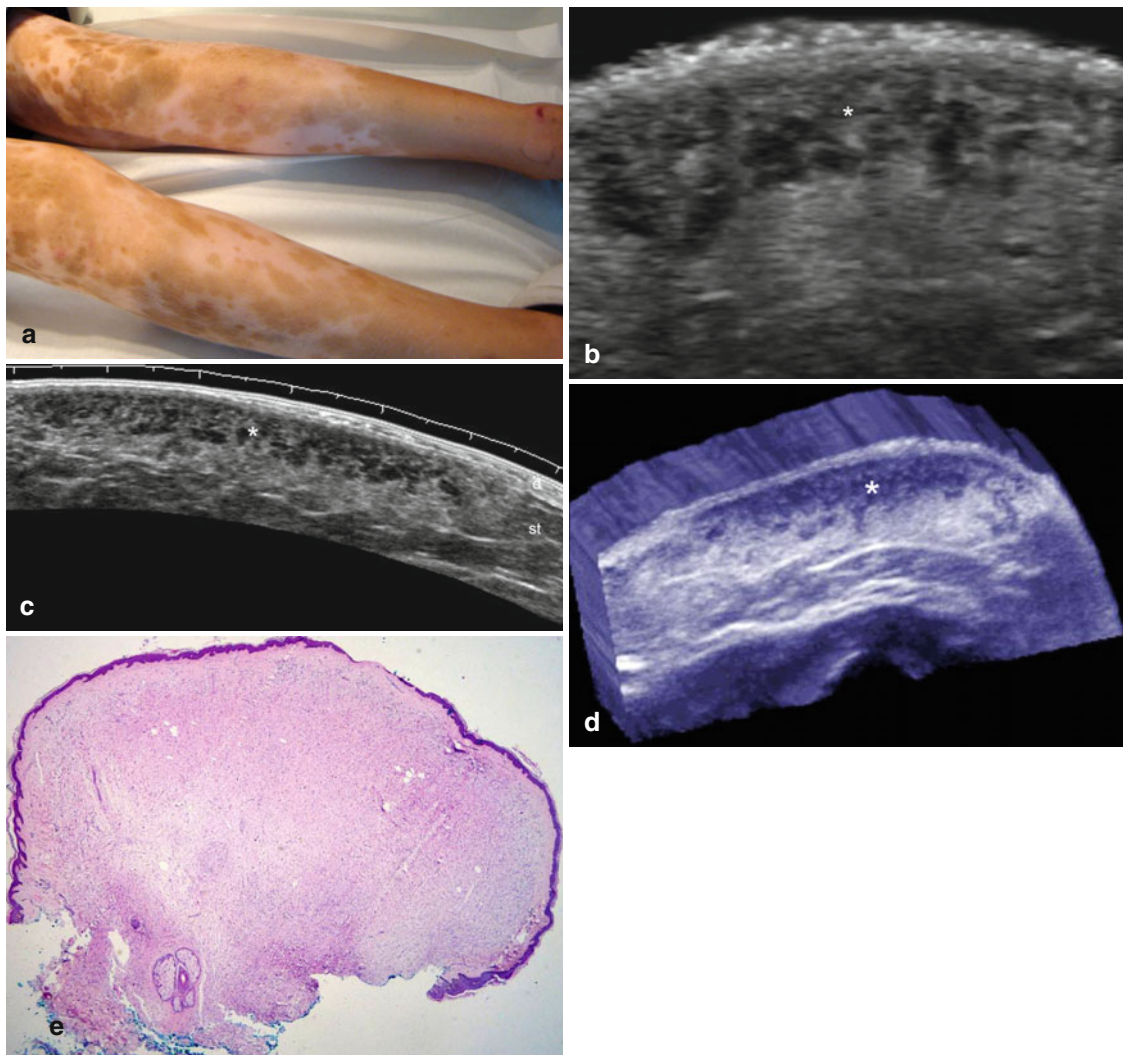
(a–e) Diffuse neurofibromatosis. (a) Clinical image shows multiple café-au-lait spots in the legs. (b, c) Grey scale ultrasound images (longitudinal views of the left leg; b extended field of view and c: zoomed image) demonstrates an ill-defined thickening of the dermis and upper subcutaneous tissue that presents heterogeneous echogenicity
